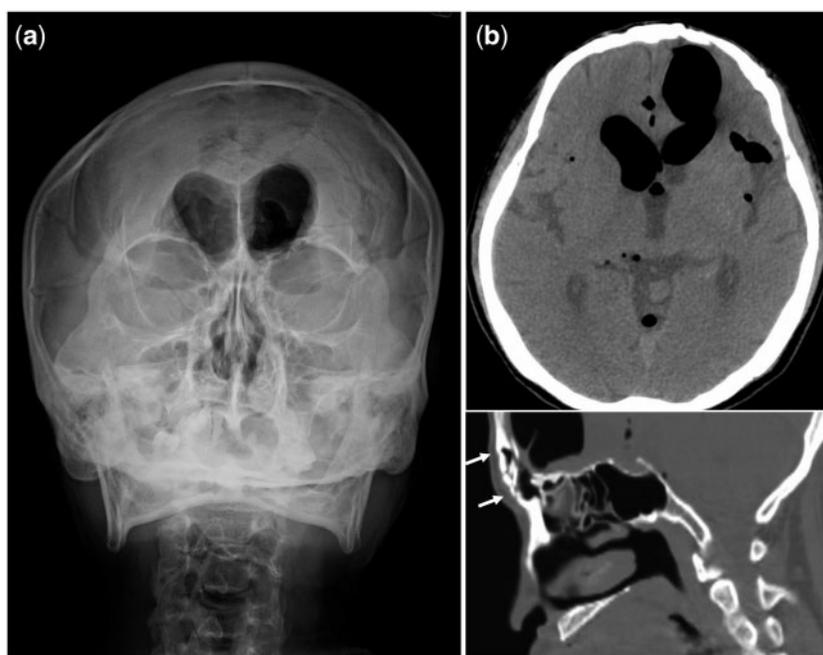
(a) Skull Water's view showing air-filled lateral ventricles. (b) The head CT showing marked air in the left frontal lobe, both lateral ventricles, third ventricle, and subarachnoid space with complicated fractures (arrows) involving frontal skull and sinus.
